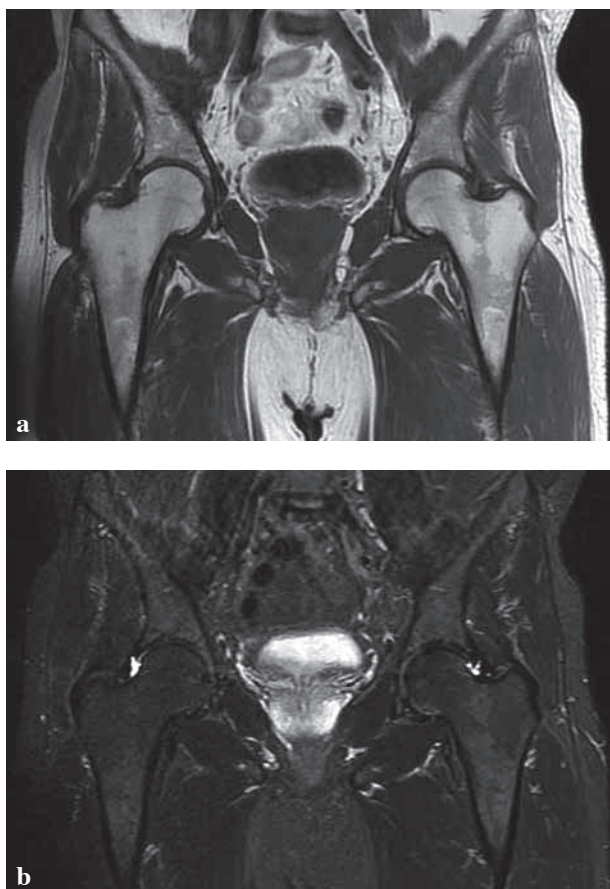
(a-b). Follow-up hip MRI showing no abnormal lesion in both femoral heads.
